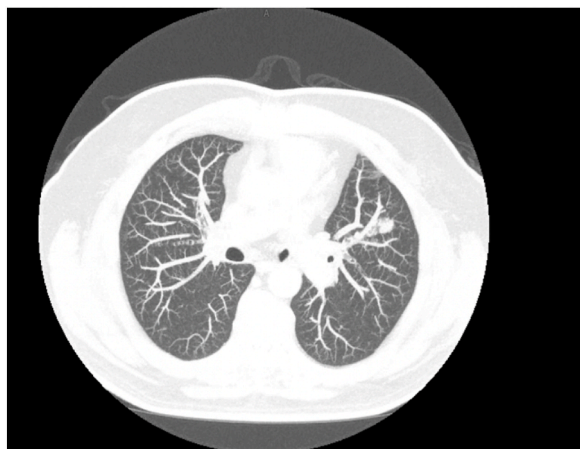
1.4×1 cm LUL nodule. PET/CT recommended for further workup.
